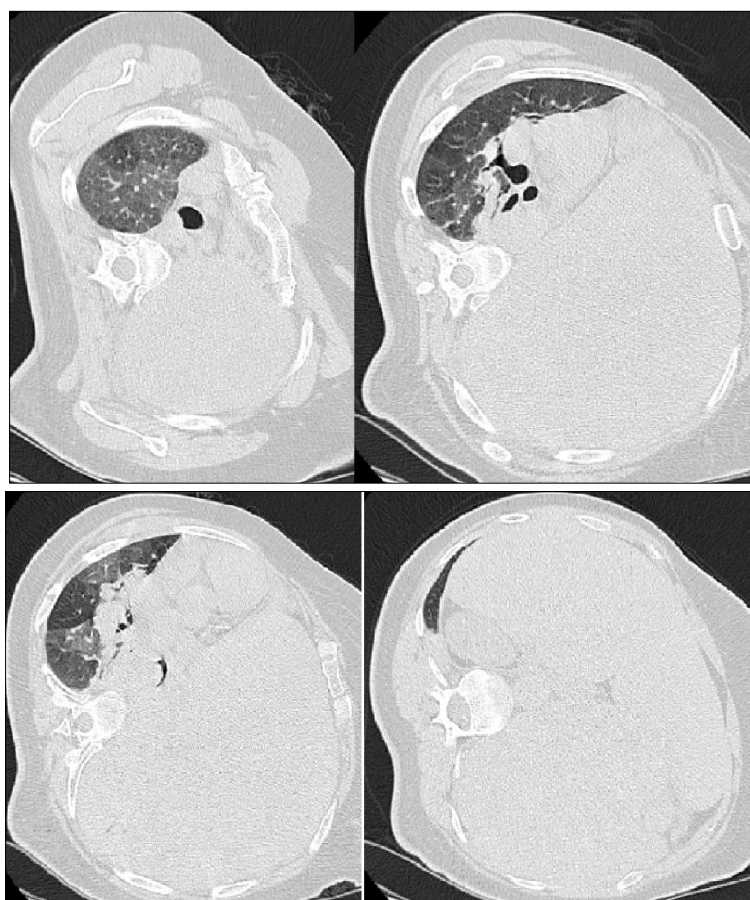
Chest CT scan showing parenchymal and mediastinal windows revealing a compressive left pleuropulmonary tumor formation with mediastinal herniation
